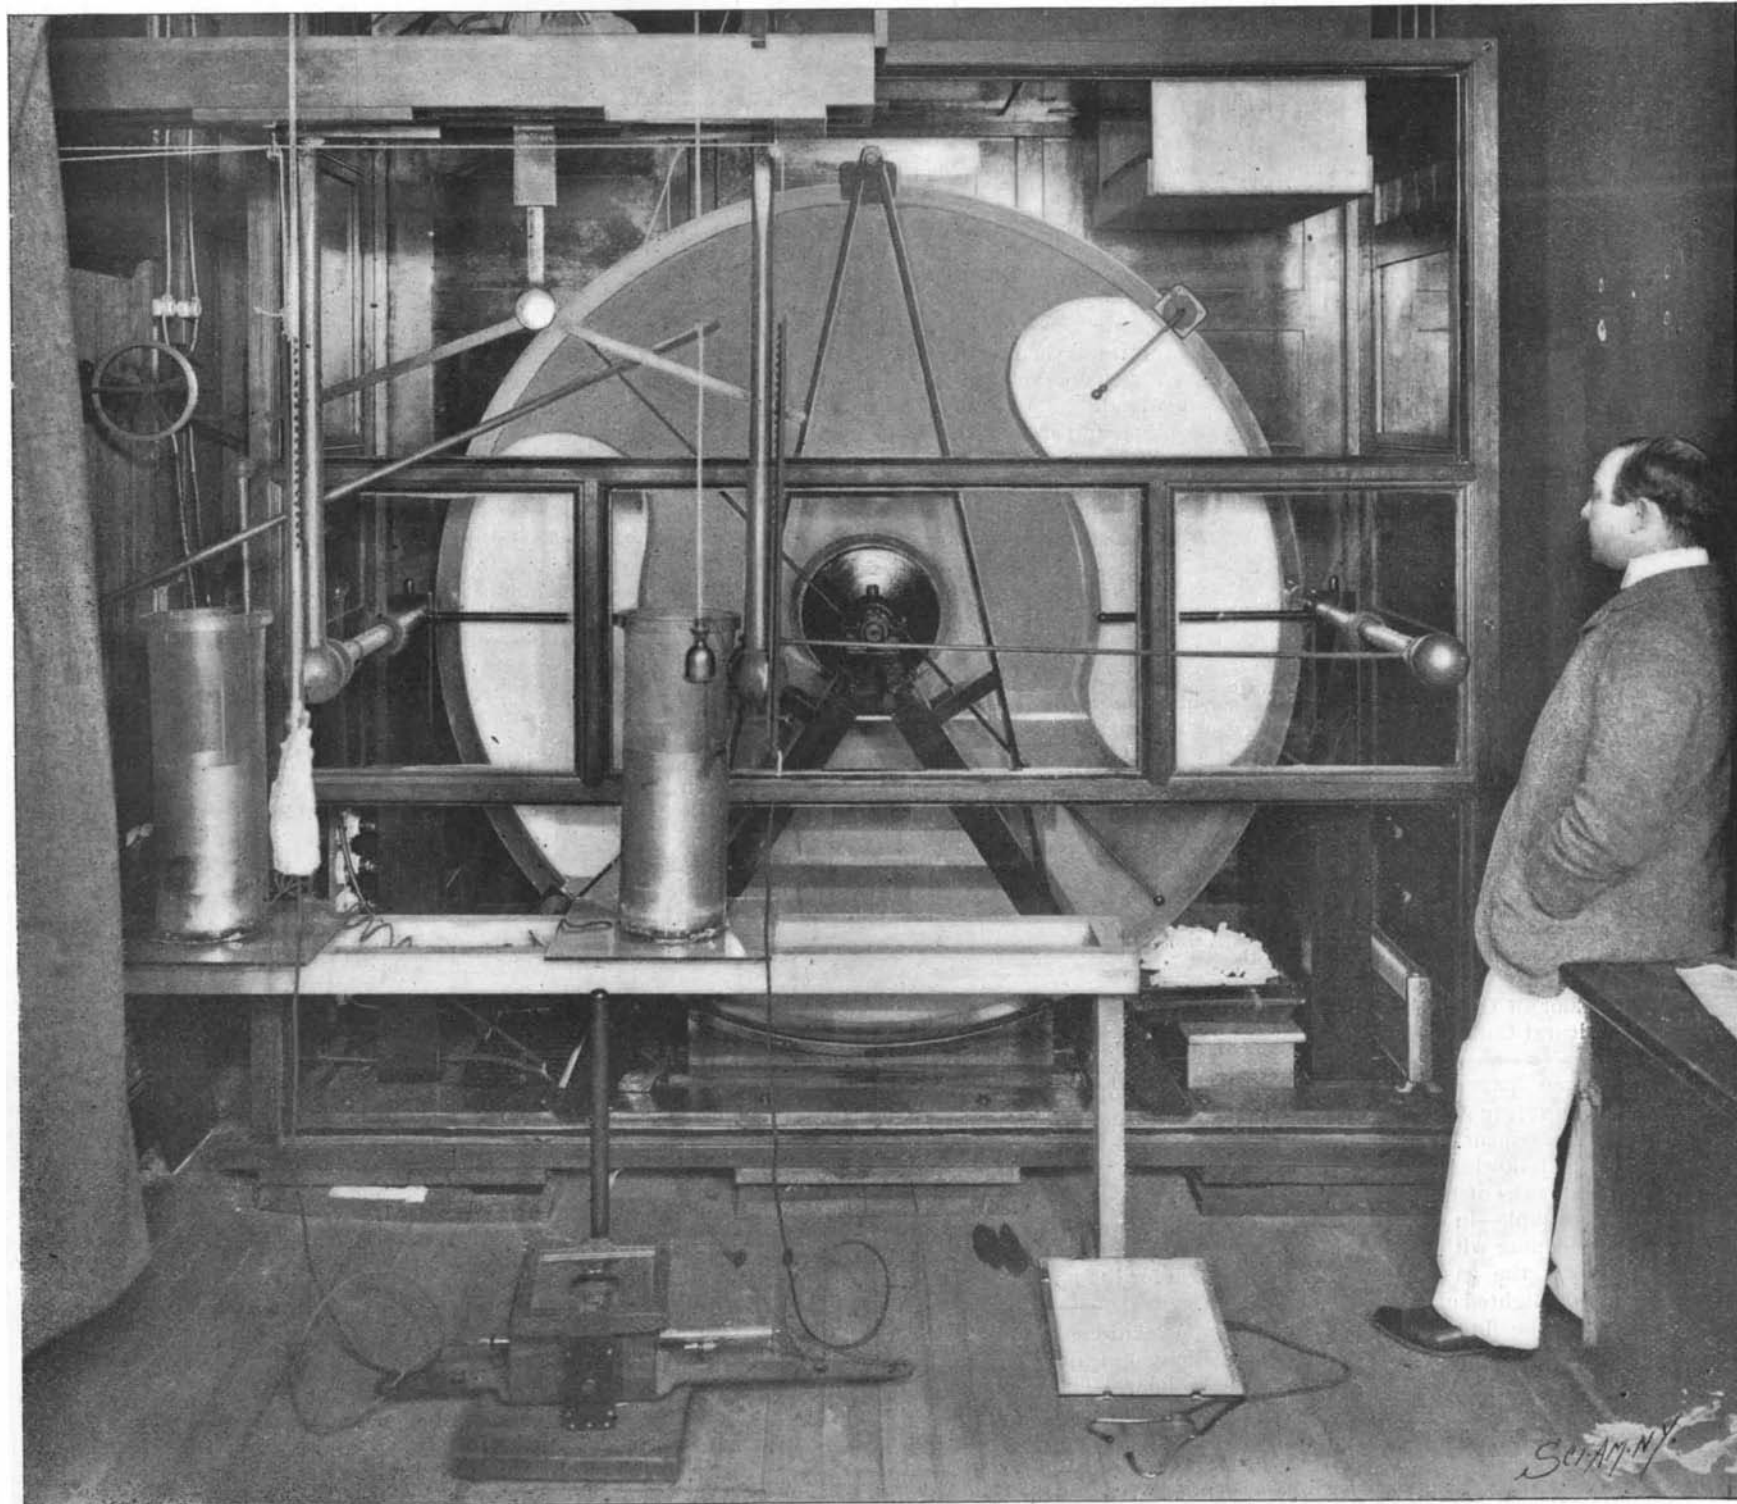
MAMMOTH STATIC MACHINE FOR X-RAY WORK.
